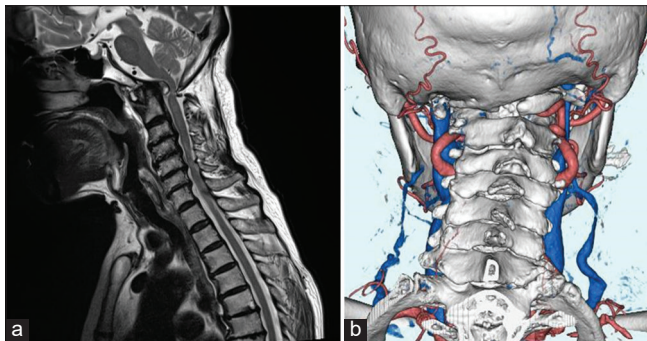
(a) Sagittal T2-WI revealed retro-odontoid cystic mass compressing the spinal cor. (b) Posterior view of three-dimensional computed tomography clearly demonstrates an assimilation with agenesis of the left VA and right VA entering the spinal canal below the occipitalized C1 posterior arch [Figures 1b and 2].
